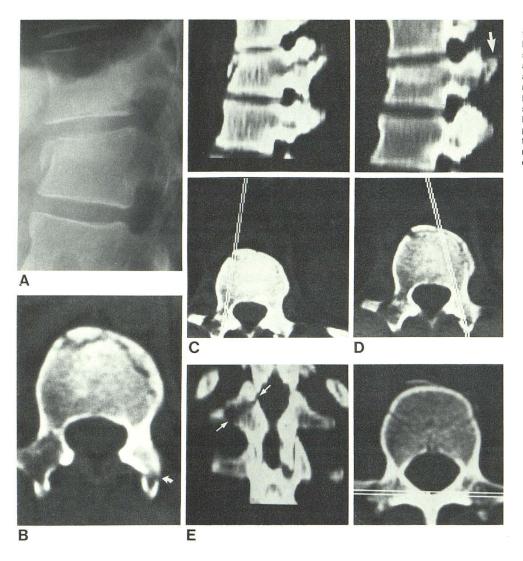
Vertebral body and bilateral facet fractures. A, L1 body compression. B, Axial CT section. Disruption of left superior facet (arrow) and questionable abnormality of right facet in addition to anterior compression. C, Parasagittal reformation through right lateral mass. Fracture extends into pedicle. D, Parasagittal reformation through left facet. Fractures superior tip (arrow) displaces posteriorly. E, Coronal image reformation verifies oblique fracture through right superior facet (arrows). Asymmetry of superior facet (tips (left is blunted).
